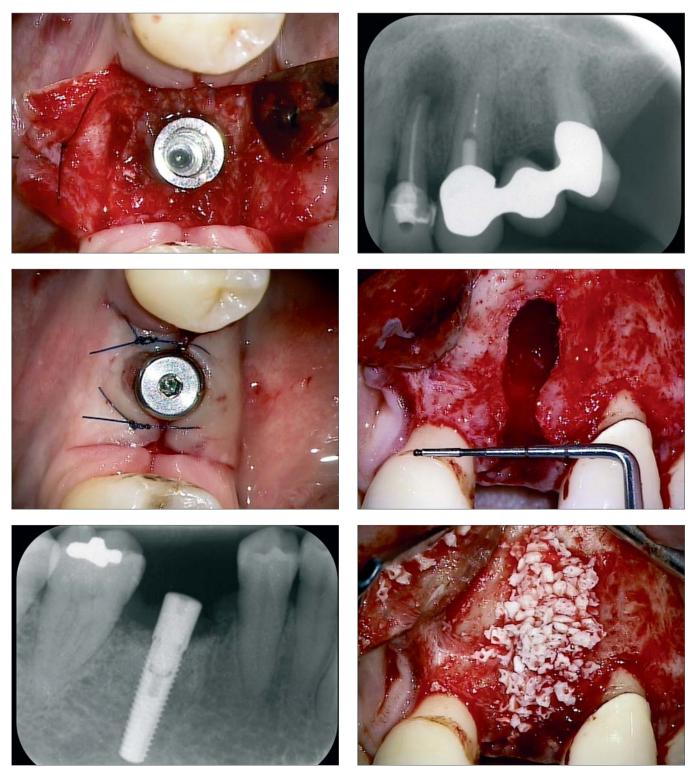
to 13: Insertion of a Camlog Screw-Line implant (4.3 mm/16 mm) with primary stability, with adequate circumferential bone thickness, fixation of the keratinised gingiva after insertion of the gingiva former, postoperative radiograph.
